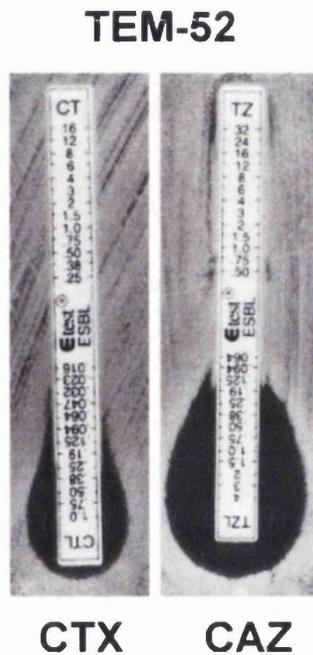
The ESBL E-test. The indicator cephalosporin is found at the upper half of the E-test strip in this case, CT is cefotaxime and TZ is ceftazidime. The lower half of the E-test strip contains the indicator cephalosporin plus clavulanic acid. Both are within an MIC gradient. In this example, a TEM-52 producing *E. coli* has a ceftazidime reading of  $>32\mu\text{g/ml}$  and a ceftazidime plus clavulanic acid reading of  $0.125\mu\text{g/ml}$ . As the ratio between the two concentrations are  $\geq 8$ , which is  $\geq$  three MIC dilution steps, the isolate is confirmed to be ESBL producing. Reproduced from Stürenburg and Mack (2003).
